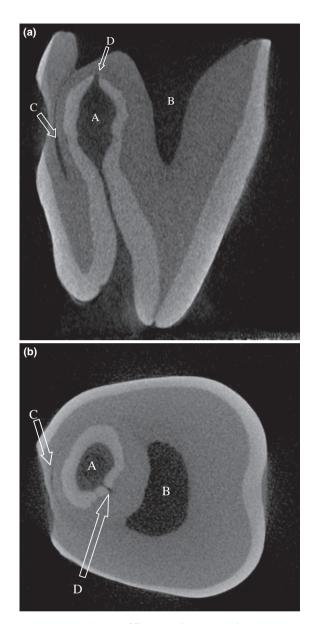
(a) Cross-sectional and (b) axial CT views of a crown of an extracted tooth affected by Oehlers' Type II invagination using a CT Scanner (Skyscan 1072; SkyScan, Kontich, Belgium). The infolding of the enamel and dentine is clearly visible (A), distinct from the main pulp (B) which has been divided to produce two distinct areas (B and C). Interruptions in the enamel layer are present in both planes (D). CT, computed tomography.
